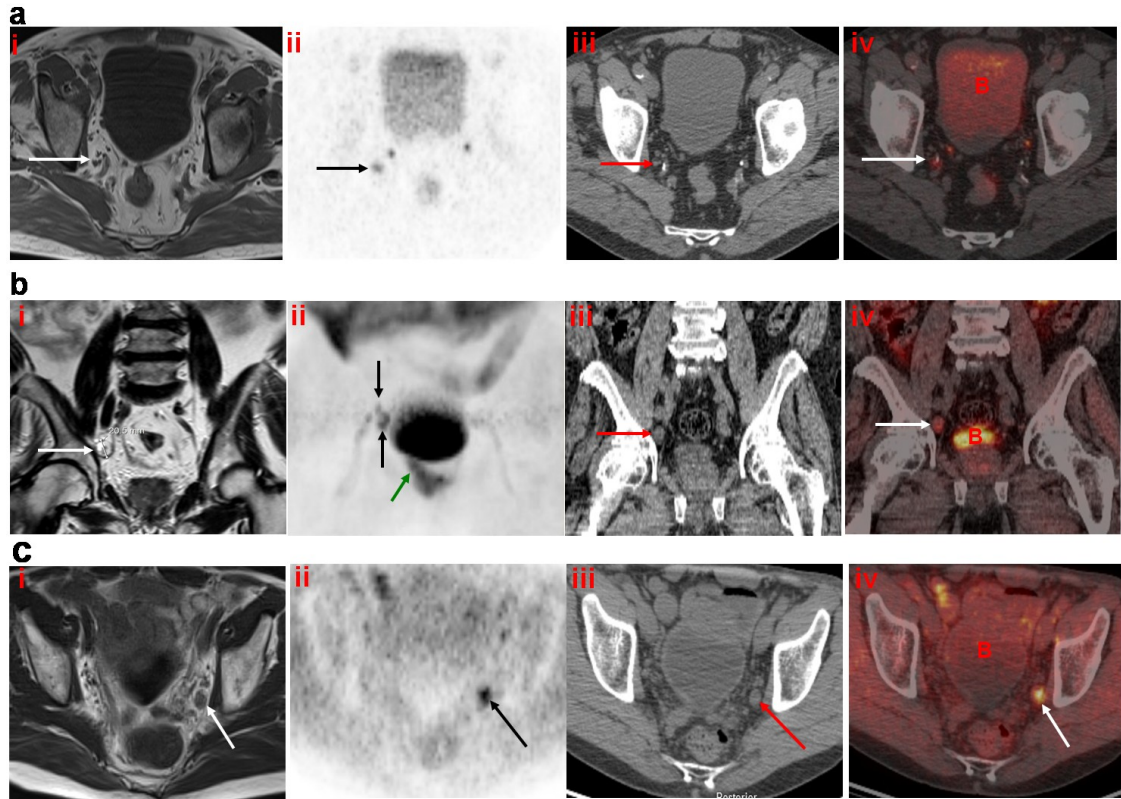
T1 weighted MRI (i), Axial [¹¹C]choline PET (ii), CT (iii), and fused PET/CT (iv) showing uptake in pelvic nodes.
